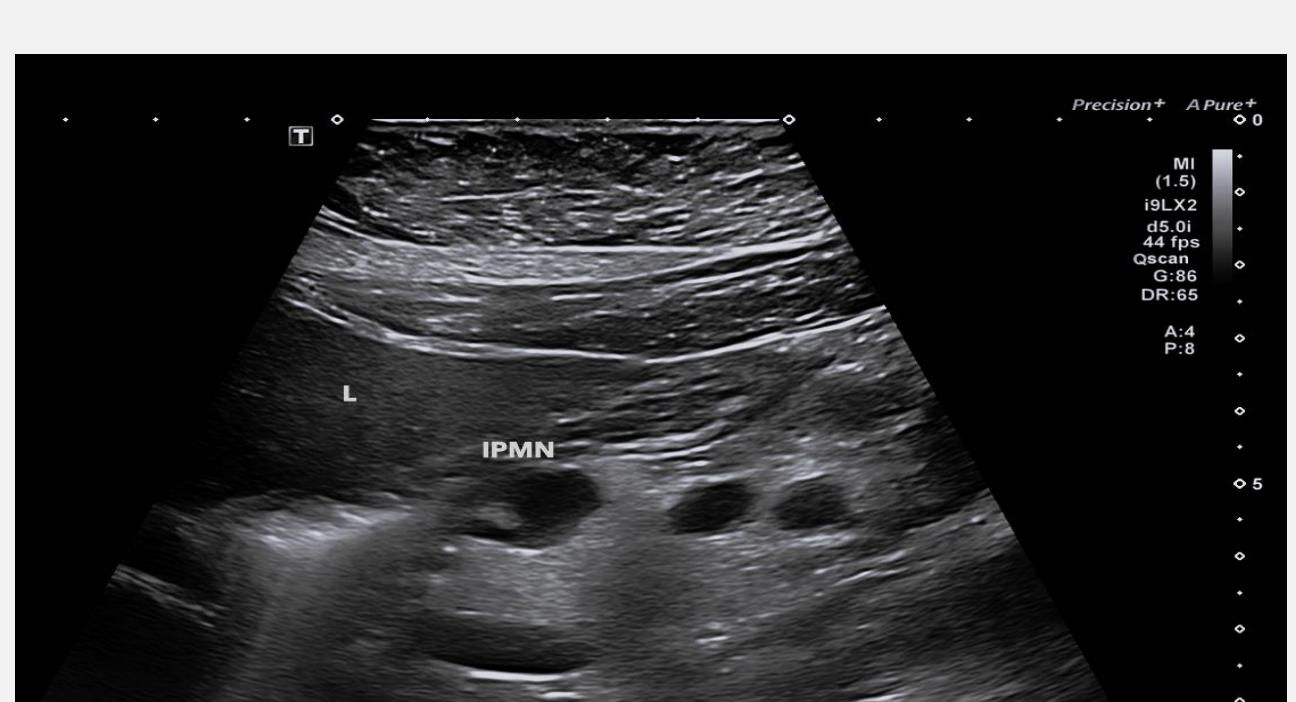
s-IPMN: 13 mm cyst in the pancreatic head (communication with the main pancreatic duct). Confirmed with MRI of the pancreas
